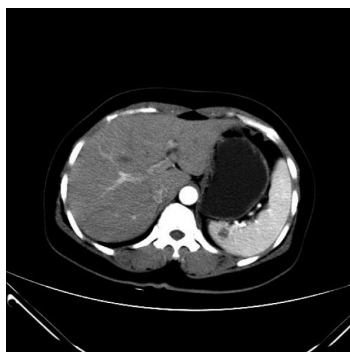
Enhancing computed tomography confirmed a hypo-dense ellipse occupying the upper pole of the spleen.
